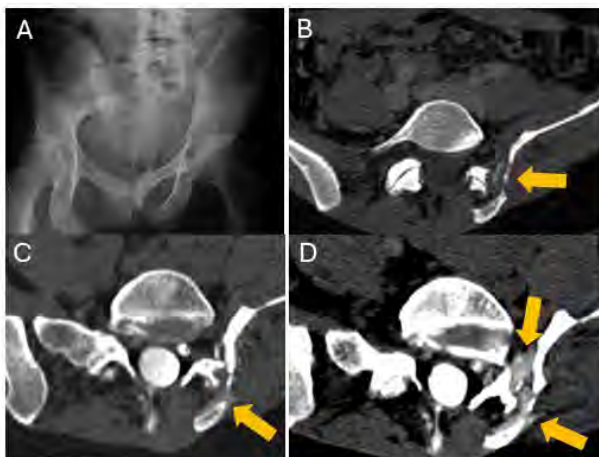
A 36-year-old patient with a history of chronic pelvic pain presented with new positional headaches. (A) AP hip radiograph demonstrates a severely dysplastic left hemipelvis. (B) Axial pelvis CT demonstrates bony fragments from a chronic pelvic fracture (arrow) in the vicinity of the left L5-S1 neural foramen. (C) Left lateral decubitus Axial CT myelogram demonstrates a trace extradural fluid collection or contrast extravasation (arrow). (D) After the patient sat upright for 5 minutes, repeat CT scan was obtained which demonstrates a new hyperdense collection along the lateral aspect of the L5-S1 facet joint and left nerve sheath (arrows).
